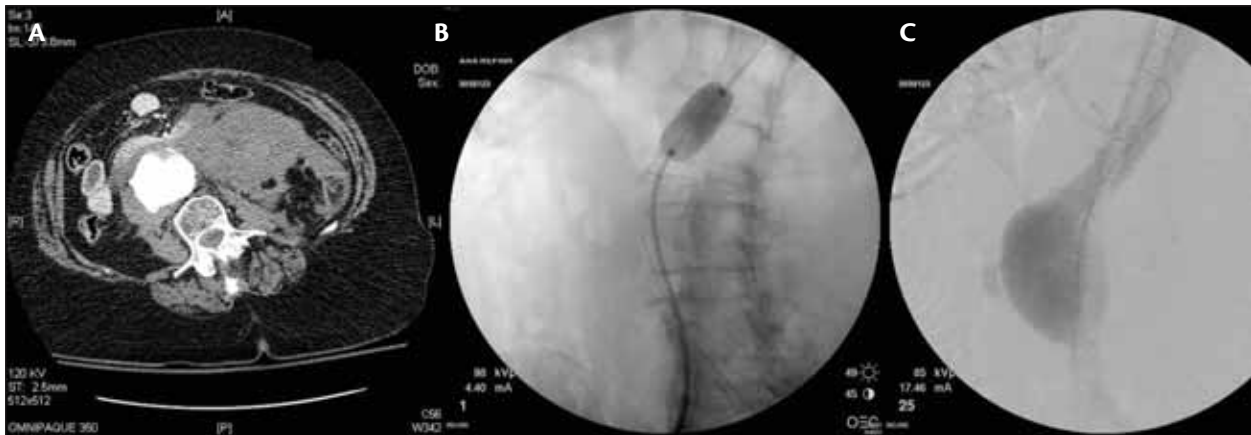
Successful endovascular repair of a ruptured infrarenal aortic aneurysm in an 82-year-old woman awake under local anesthesia. Axial CT image of the large ruptured aneurysm (A). Remote aortic balloon occlusion (B). Aortic stent graft in position before deployment; the aortic balloon has been removed. Note the active extravasation of contrast along the anterior wall of the aneurysm (C).
